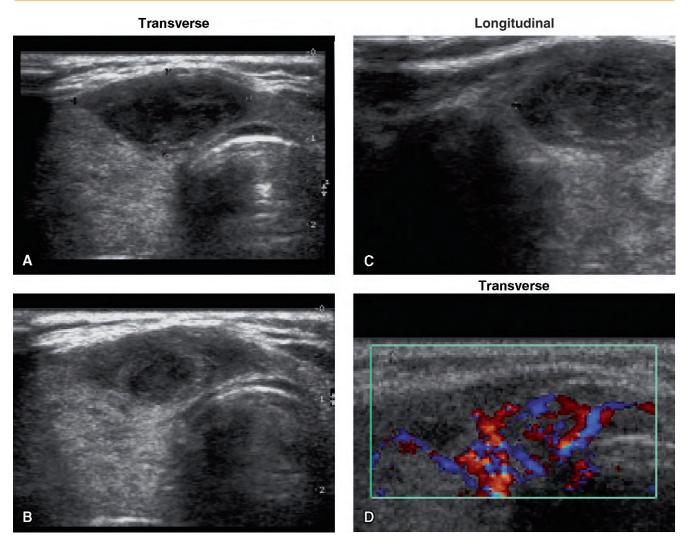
Ultrasound of papillary thyroid carcinoma in the isthmus. A, Transverse, 9 x 20 mm. B, Transverse. C, Longitudinal, 15 mm. D, Color Doppler, transverse.
